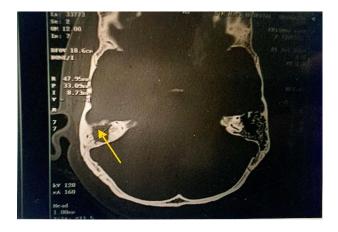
Axial cut of CT temporal bone showing right sided cholesteatomatous mastoid cavity.
